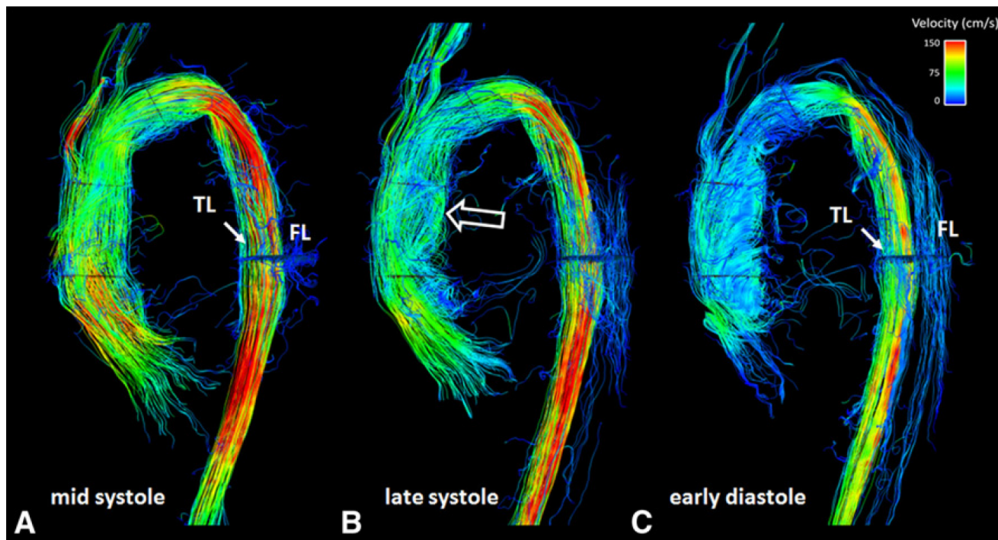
Velocity streamlines derived from 4D-flow MRI data throughout the cardiac cycle presented by François et al. (2013).
